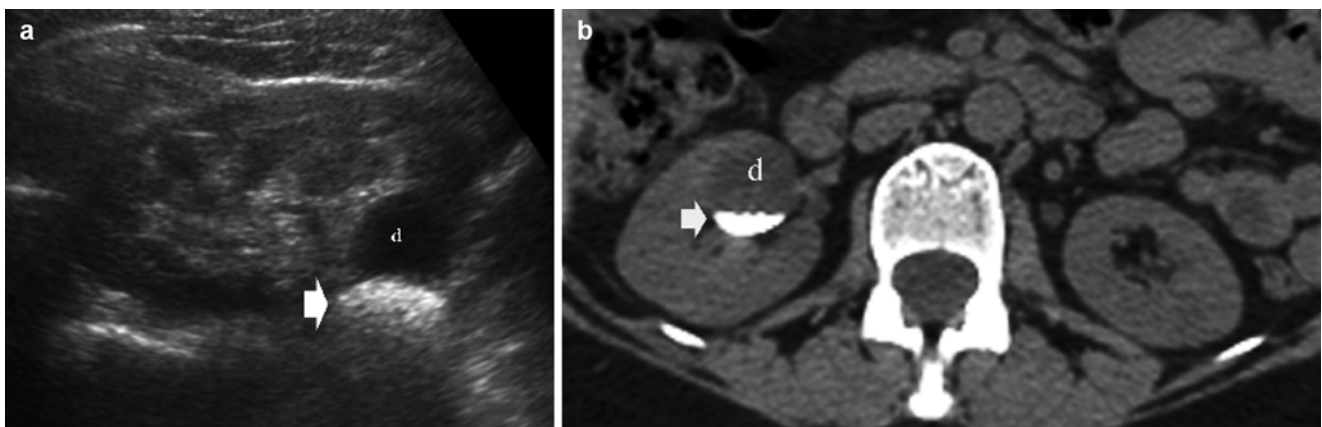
(a) Ultrasound of the right kidney demonstrating echogenic stone (*arrow*) within a calyceal diverticulum indicated by the letter *d*. (b) Unenhanced CT demonstrating the renal stone (*arrow*) within a calyceal diverticulum indicated by the letter *d*
